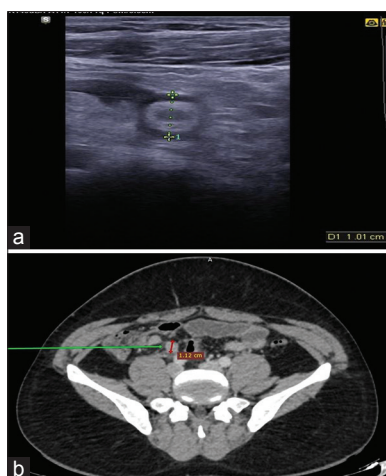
(a) Ultrasound, (b) CECT abdomen axial section
